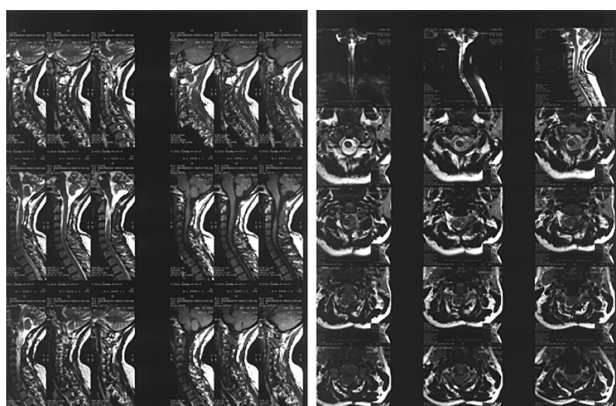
The Cervical MRI two months after the conservative treatment.
